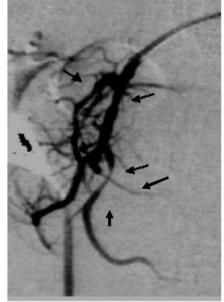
Vasospasm on angiographic appearance in a patient with acute necrotizing pancreatitis 12 hours after the onset. CE-CT revealed a heterogeneously perfused area of the pancreatic head. Selective angiography via the gastroduodenal artery demonstrated vasospasm such as sudden tapering (short arrow) and alternative narrowing and dilatation (long arrow) of the intrapancreatic branch arteries, consistent with the poorly perfused area on CE-CT. based on the angiographic appearance by Hirota et al. (13) Severe vasospastic changes of both the celiac artery and the superior mesenteric artery were observed simultaneously in patients with NOMI accompanied by ANP. Severe ischemic changes in the intraabdominal vessels may aggravate microcirculation not only in the pancreas but also in the abdominal viscera leading to pancreatic necrosis and systemic organ failure.
